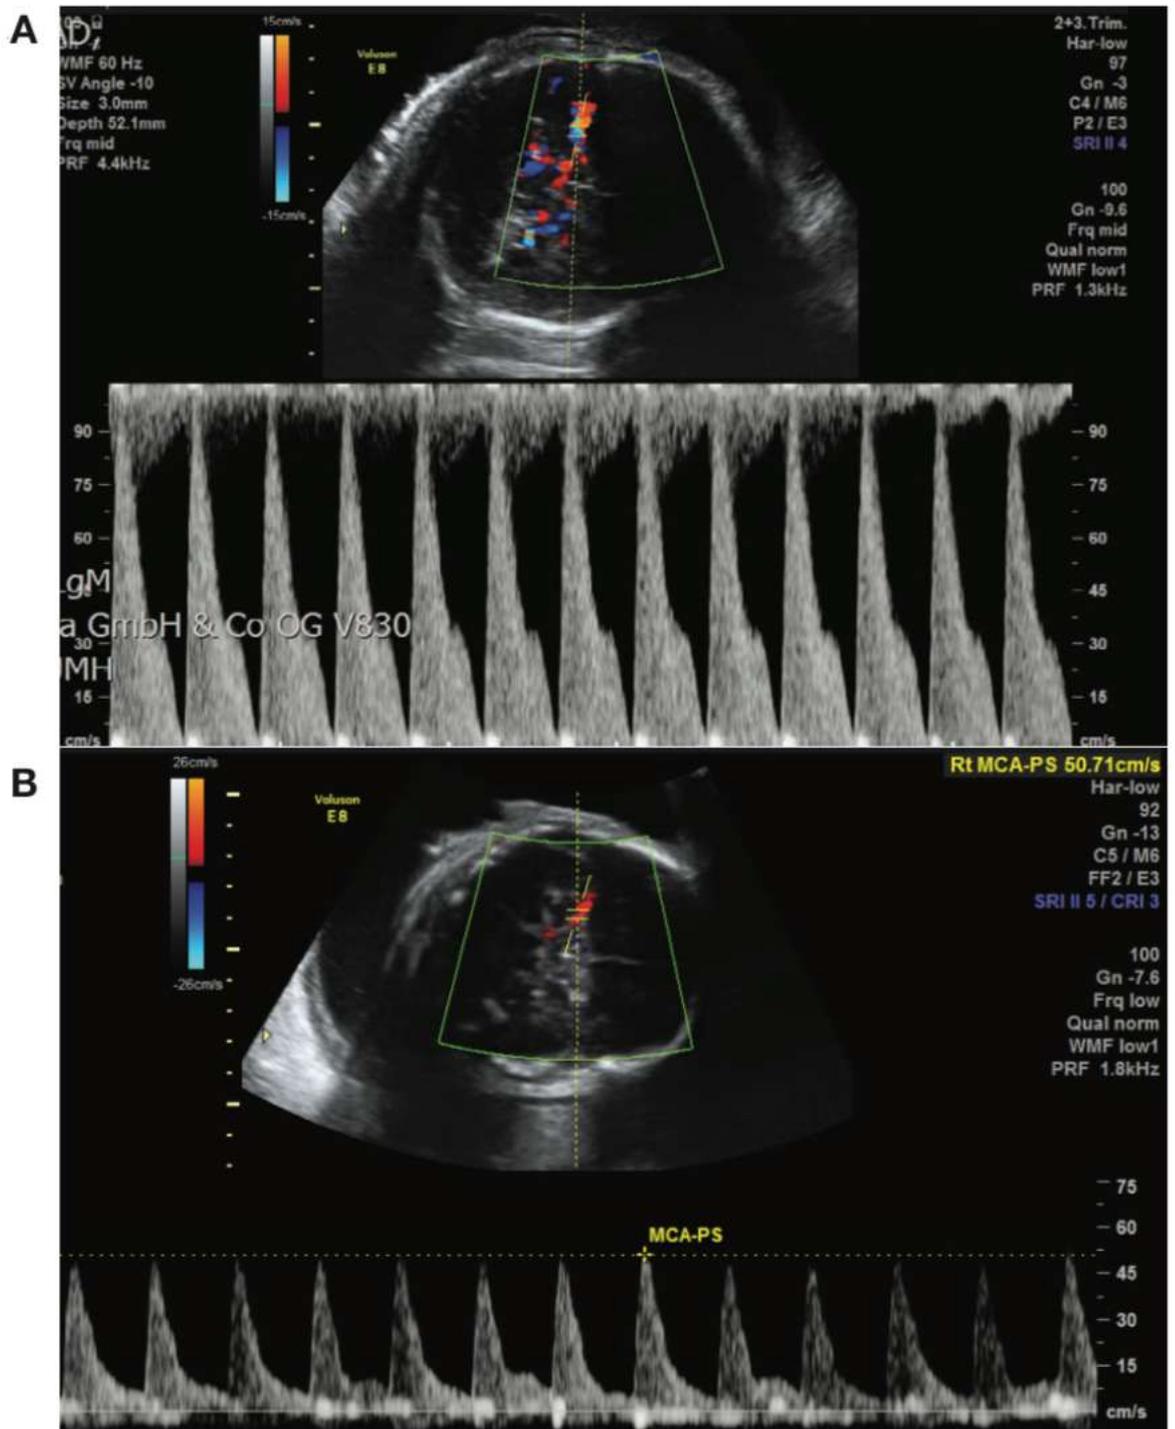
Middle cerebral artery Doppler waveform analysis of (A) a fetus with anaemia secondary to rhesus disease demonstrating an increased peak systolic velocity and (B) the same fetus 48 hours following an intrauterine transfusion.
